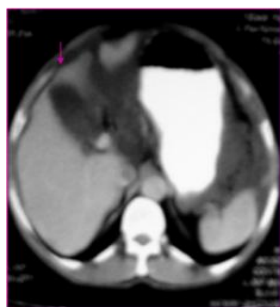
CT showing scalloping
